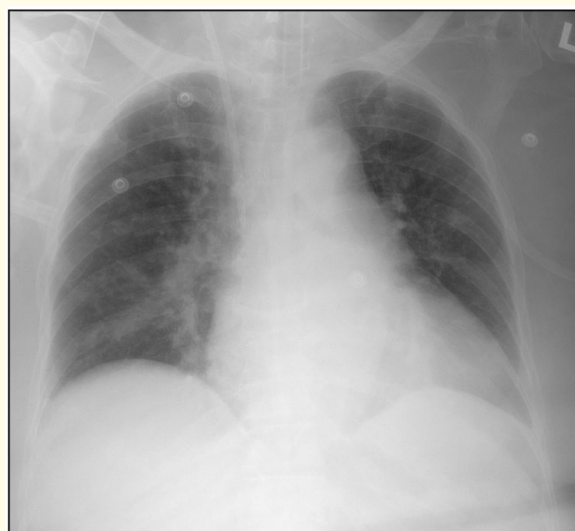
Chest X-ray upon initial encounter at emergency.
